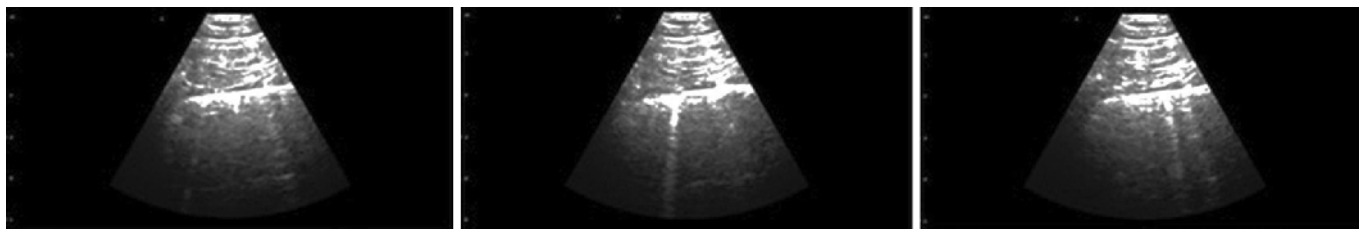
The three images show consistent character of the ultrasound speckle pattern from stable tissue above the pleural line, indicating very slight motion of the transducer, and the high degree of variation of the comet character, location, and number below the pleural line during a few seconds duration lung exam.
